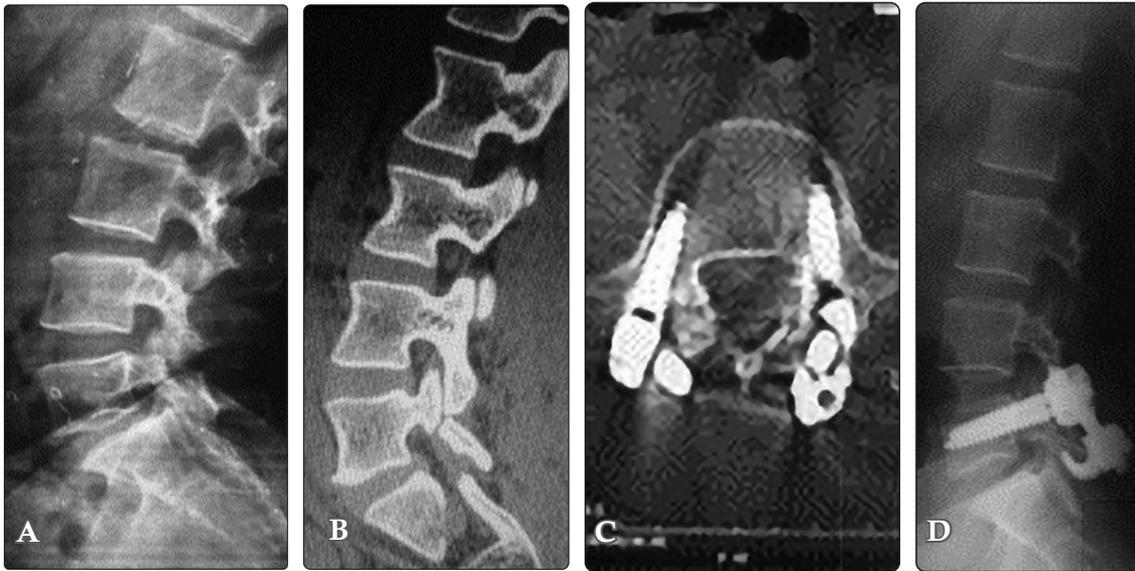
A 24-year-old female patient presenting with low back pain persistent for one year and not responding to medical treatment. (A) Plain radiograph and (B) MSCT-scan showing L5 spondylolysis. Pars reconstruction was done using screw rod laminar hook system. (C) Postoperative axial CT scan showing screw purchase. (D) Plain lateral view radiograph 6 months postoperatively showing healing pars.
